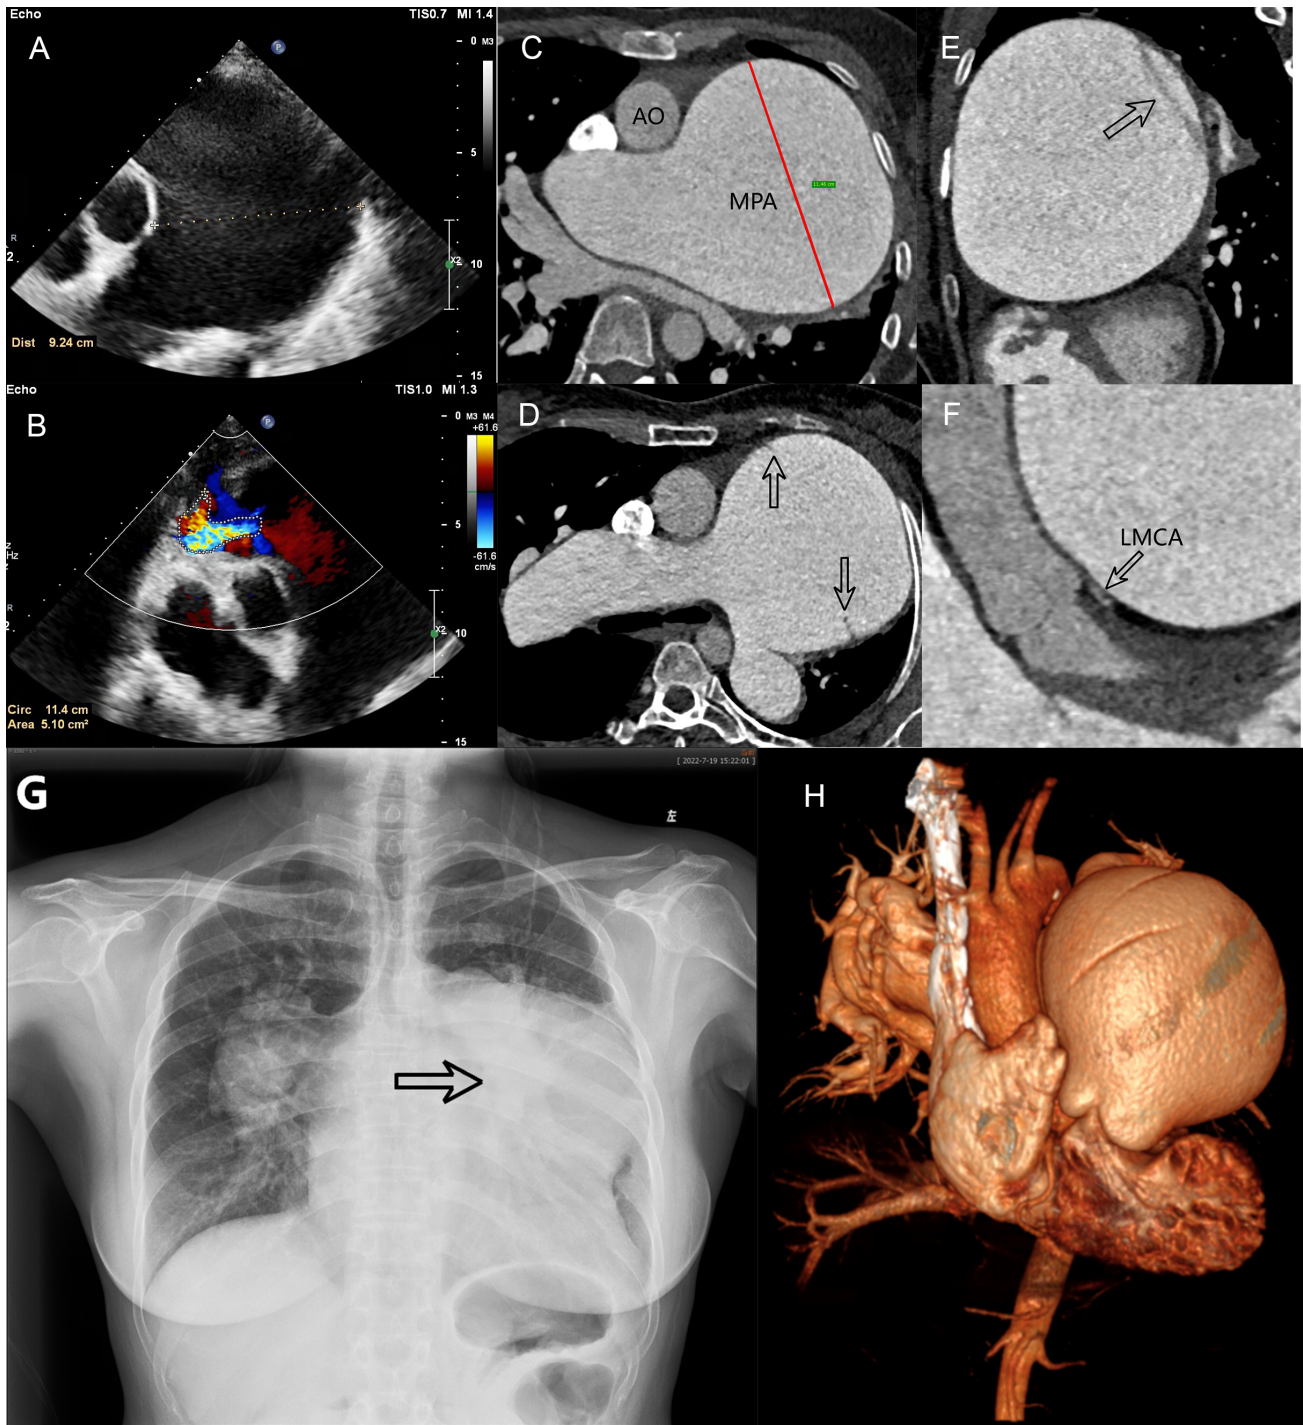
The preoperative imaging findings. Imaging examinations revealed a giant pulmonary artery aneurysm (PAA) (Panel A, C, G, H) and dissection (arrow, (Panel D, E)) with a computed tomography angiography (CTA) diameter of 114.6 mm and an echocardiography diameter of 92.4 mm, respectively. The PAA also caused extrinsic compression of the left main coronary artery (left main coronary artery (LMCA); arrow, (Panel F)). Echocardiography showed a pulmonary regurgitation (PR) area of 5.1 cm² (Panel B).
